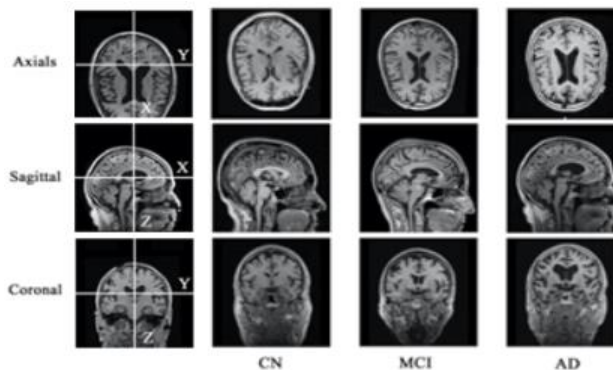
Different brain planes of patients' MRI images with CN, MCI, AD
